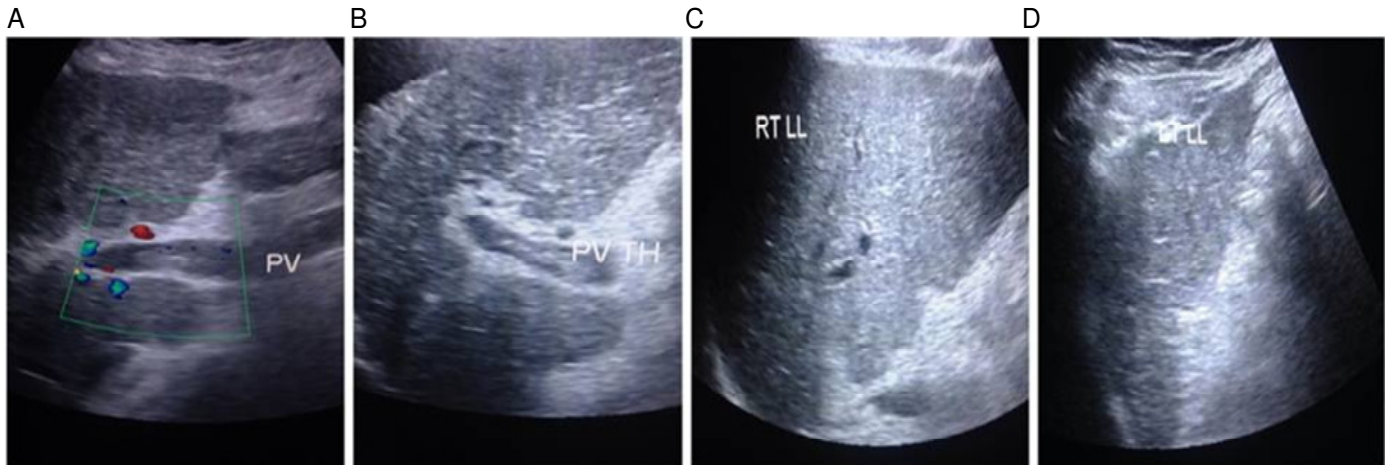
Liver Ultrasonography (US) and Color Doppler US of portal system. A: Dilated main portal vein with echogenic thrombus occluded near totally its lumen with no detected color flow or Doppler signals inside; B: Thrombus occluded near totally the lumen of portal vein; C: Right lobe of the liver lobe shows cirrhotic changes with no detectable focal lesions; D: Left lobe of the liver shows cirrhotic changes with no detectable focal lesions.
